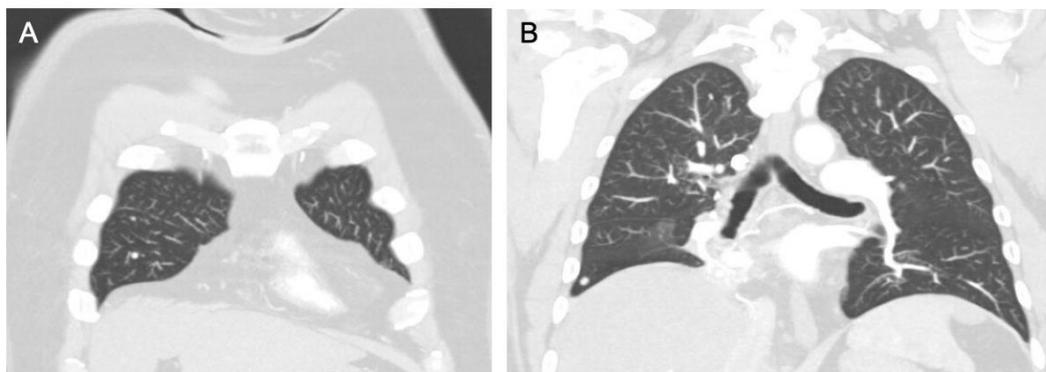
Computed tomography scan of chest with intravenous contrast showing A) two hyperenhancing nodules in the right middle lobe of the lung and B) one hyperenhancing nodule in the right lower lobe of the lung.
